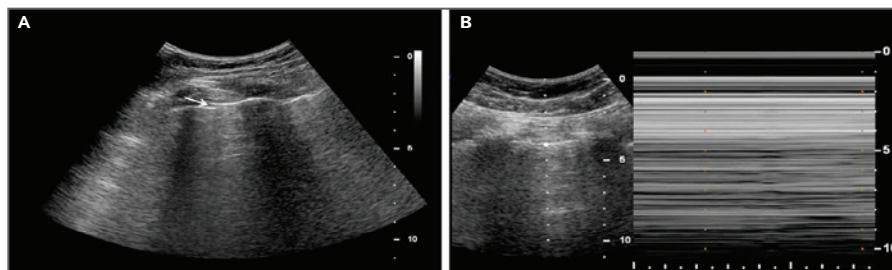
Ultrasound Images of the Lung with Features of Pneumothorax.
